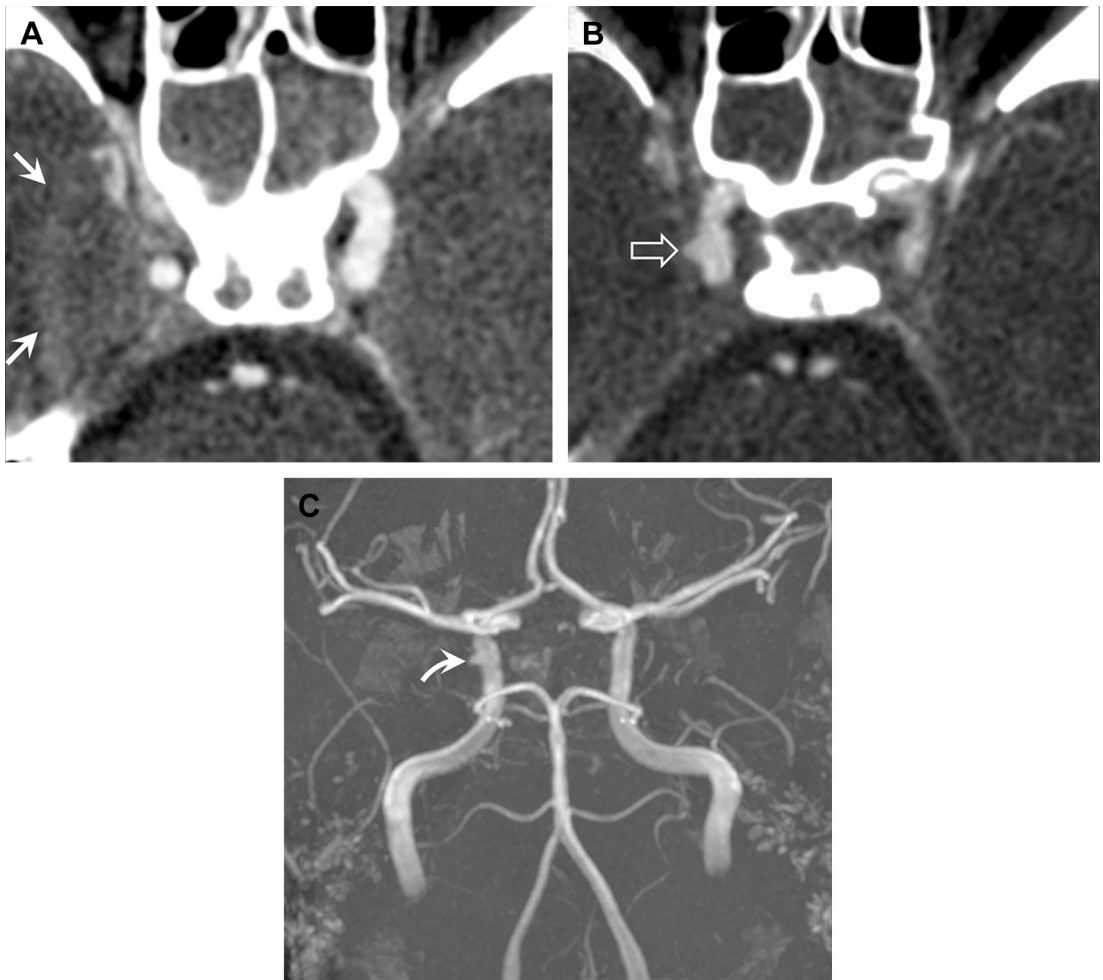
Small traumatic internal carotid pseudoaneurysm. (A, B) CTA images reveal a large parasellar epidural hematoma (arrows) with a probable small traumatic ICA pseudoaneurysm (open arrow). (C) The aneurysm (curved arrow) is confirmed on a 3D-TOF MIP image. Extensive central skull base fractures likely partially avulsed an intracavernous ICA branch from the parent artery.
